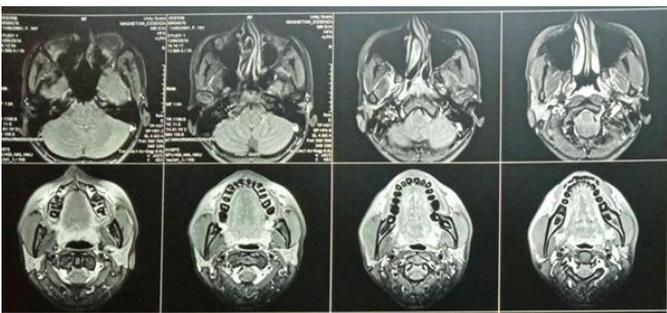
MRI Revealing Hypertrophic Masseter Muscle At The Right Side
